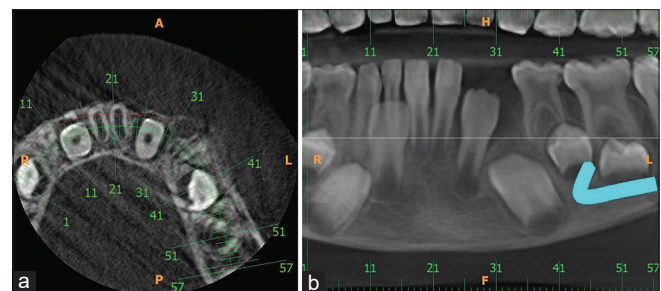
Cone beam computed tomography showing localized mixed radio-opaque–radiolucent lesion in the buccal aspect extending from the distal aspect of 32 to the mesial aspect of developing 34. (a) Axial view (b) Panoramic view
